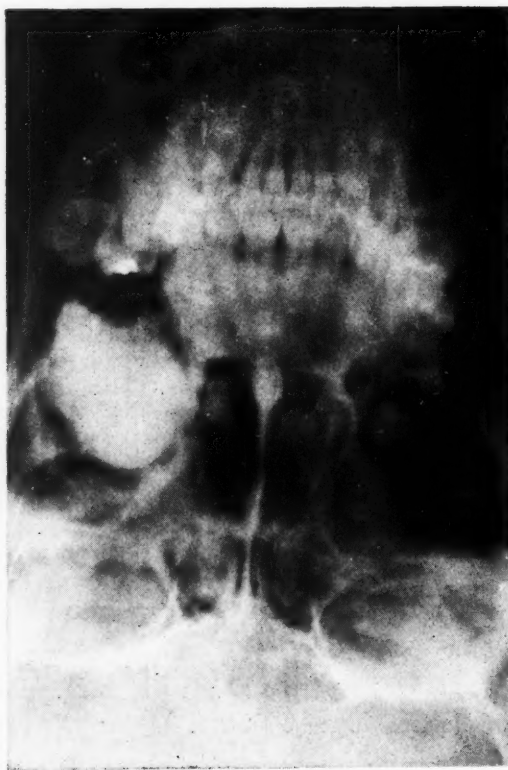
Anteroposterior extraoral roentgenogram showing radiopaque object in right maxillary sinus, surrounded by small radiolucent area.
